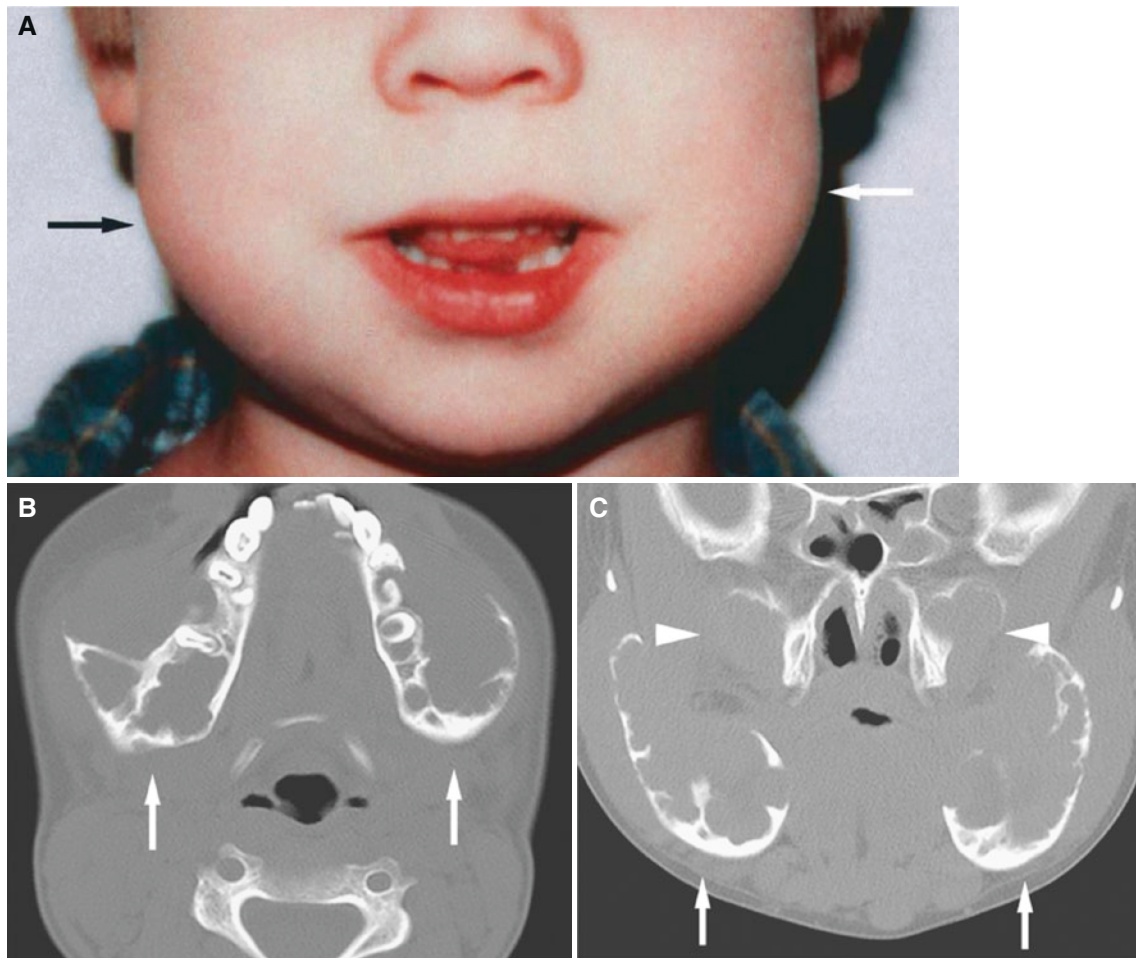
Cherubism; 6-year-old male with gradually increasing swelling of the face and mandible bilaterally. (A) Clinical photograph shows bifacial swelling (arrows). (B) Axial CT image shows expanded jaw
